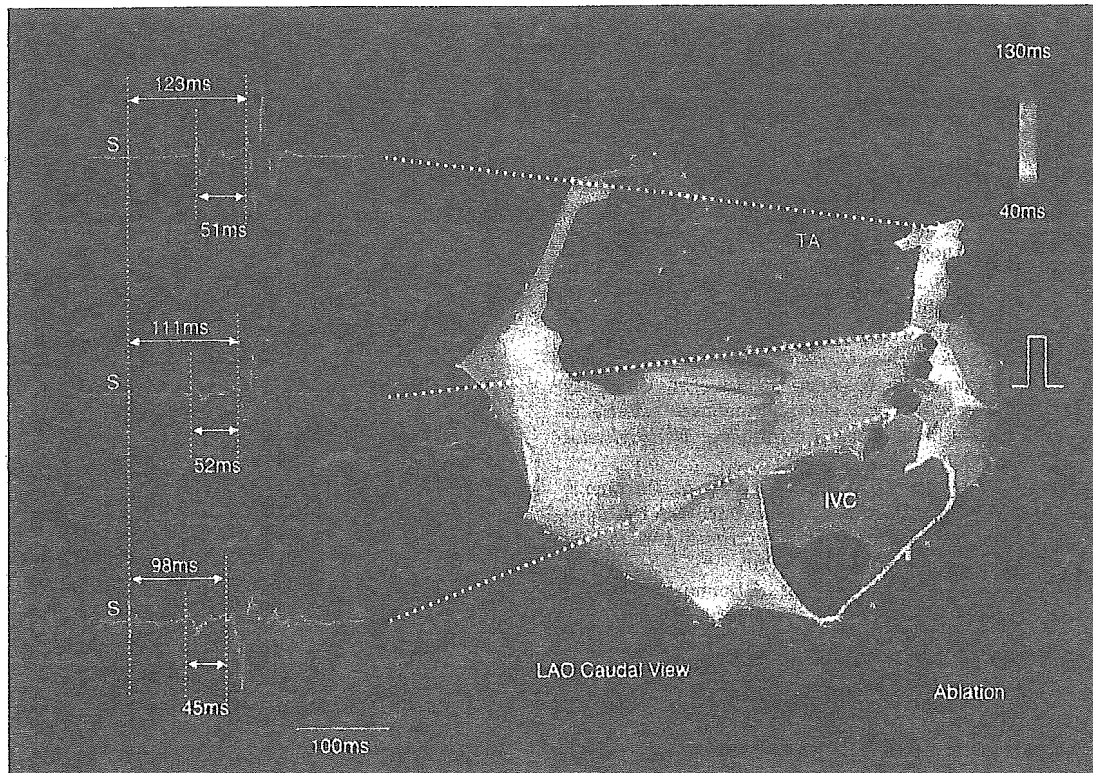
A CARTO remap after the isthmus ablation during proximal CS pacing (right) and the bipolar electrograms recorded on the ablation line (left) in the same patient as in Fig. 4. Right panel, A wavefront from the posterior wall due to the transversal conduction across the CT pre-excited the lateral part of the isthmus earlier than the CCW wavefront around the TA and collided with the CCW wavefront at the lateral wall (purple region). The color bar indicates the activation time of each site, depicting the earliest activation site as red and the latest activation site as purple. Left panel, The shortly-split double potentials were recorded on the ablation line at the tricuspid annular, middle, and inferior vena caval parts, respectively. IVC: inferior vena cava; S: pacing stimulus; TA: tricuspid 4 annulus.
